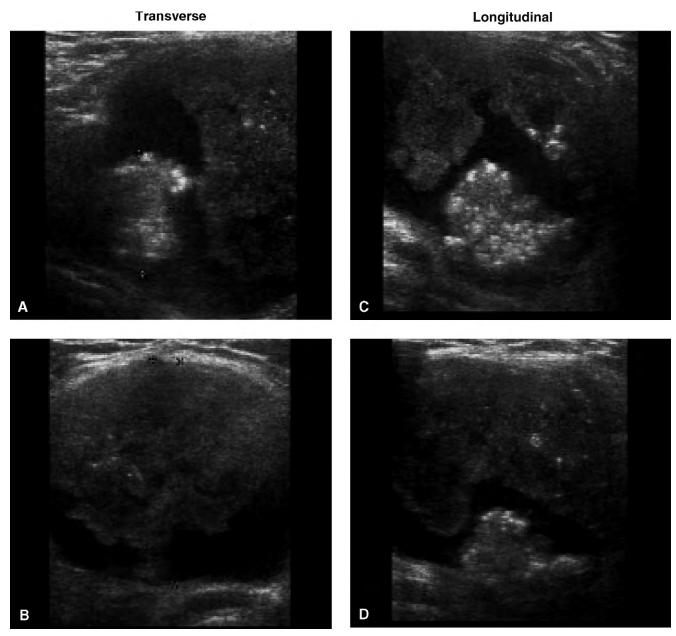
Ultrasound of partially cystic papillary thyroid carcinoma in the isthmus and left lobe. A and B, Transverse. C and D, Longitudinal.
